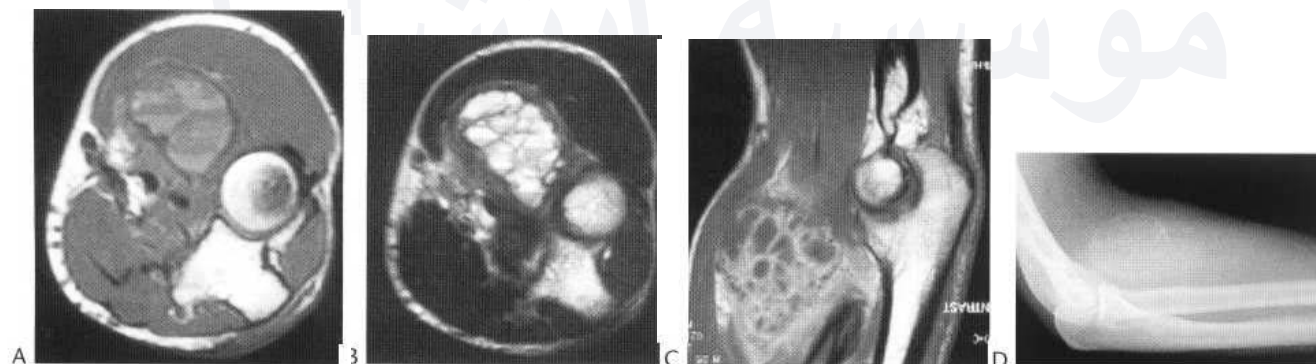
Subacute myositis ossificans in the antecubital fossa in a 25 year old referred with a potential diagnosis of a desmoid/sarcoma (prior trucut biopsy was reported as being inconclusive) on (A) transverse T_1 -weighted SE, (B) transverse T_2 -weighted FSE, (C) sagittal postcontrast T_1 -weighted SE images and (D) lateral radiograph of the elbow. The plain radiograph shows the characteristic peripheral ossification and multiple high-signal fluid-fluid levels from haemorrhage on the MR images.
